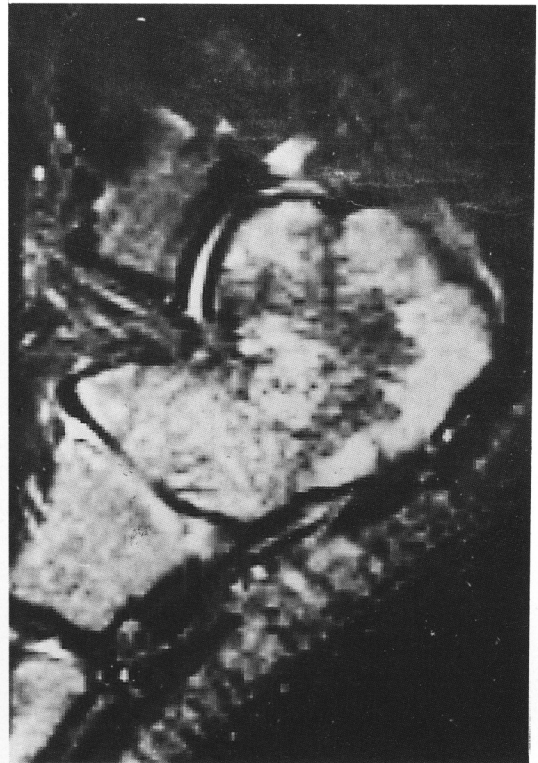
T2-weighted images shows heterogeneous high signal change of the lesion.
